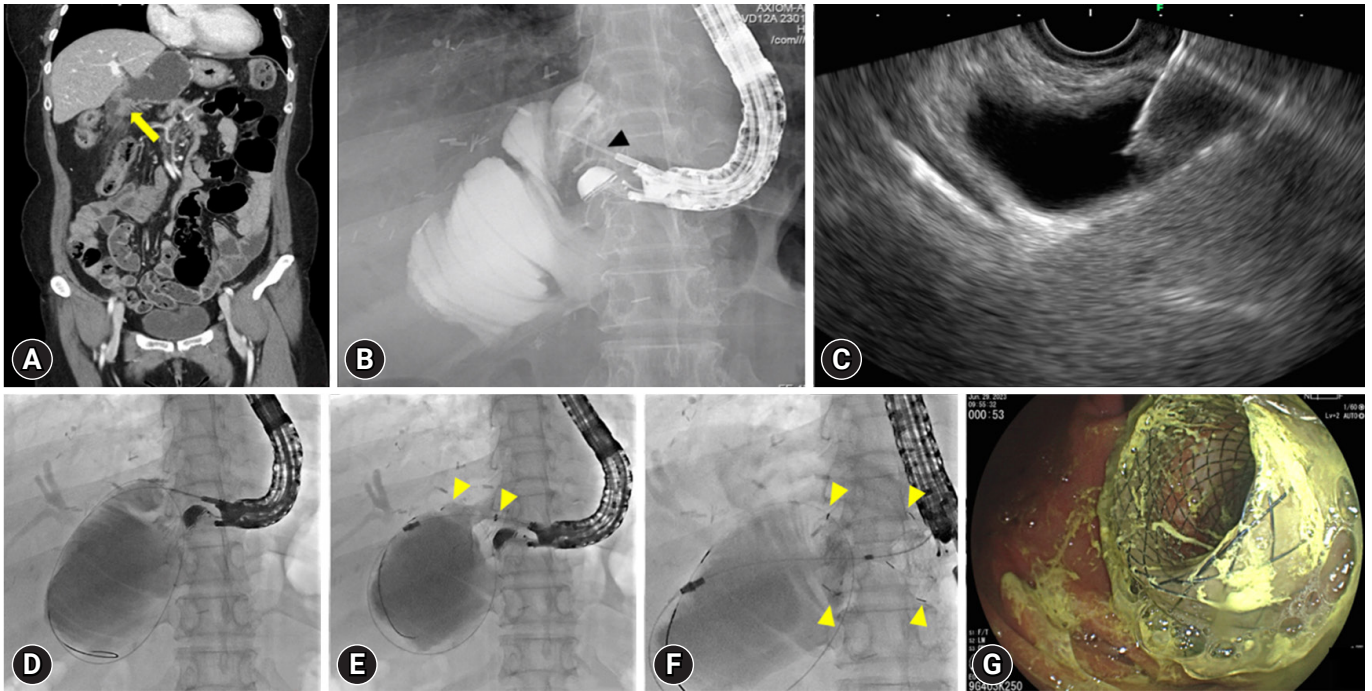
An example of endoscopic ultrasound (EUS)-guided gastrojejunostomy in a patient with recurrent intraductal papillary neoplasm of the bile duct and long afferent loop stricture undergoing right anterior partial sectionectomy, S1 and radical bile duct resection, and subtotal gastrectomy with Billroth-II reconstruction. (A) A coronal image of the dilated afferent loop caused by mid afferent loop stricture (yellow arrow) on computed tomography scan. (B, C) A needle puncture (black arrowhead) on fluoroscopic and EUS view. (D) A guidewire insertion through the punctured needle into dilated afferent loop. (E) Stent (yellow arrowheads) deployment along the inserted guidewire. (F, G) Completed stent (yellow arrowheads) deployment on fluoroscopic and endoscopic view.
